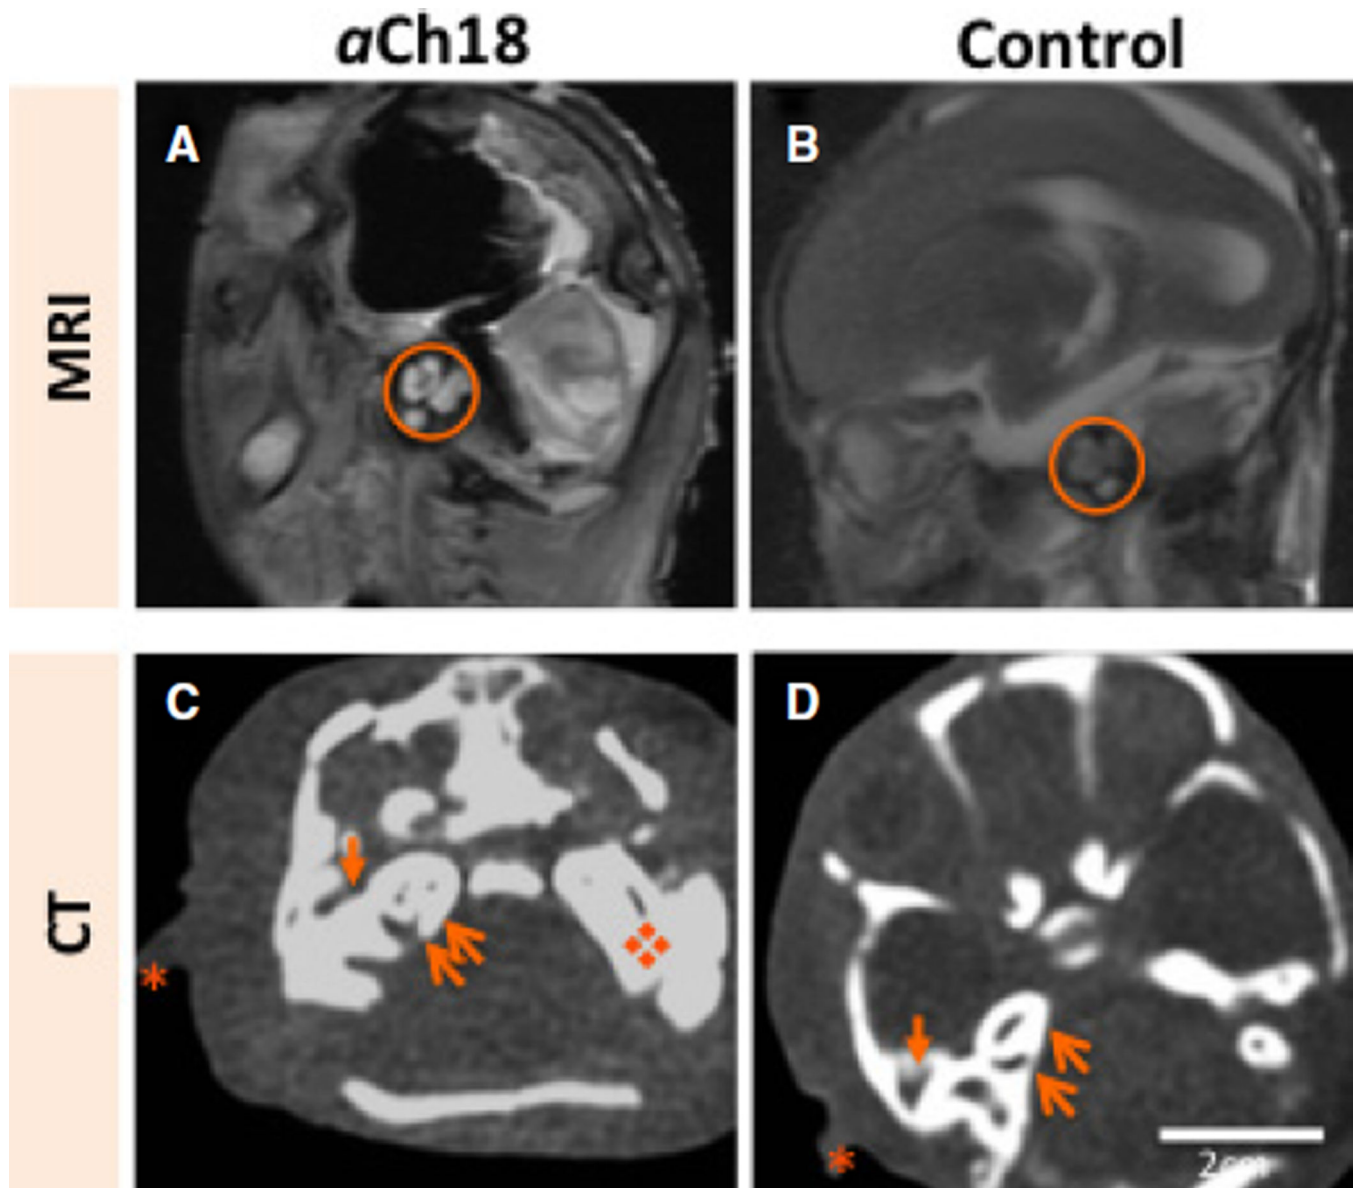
Internal, middle and external auditory structure development in HPE and cyclopia. (A) Sagittal magnetic resonance imaging (MRI) of the lateral head of an aberrant Ch18 (*aCh18*) fetus showing the middle auditory structures, mainly the ossicles (circle) appearing radiodense in *aCh18* compared with (B) the age-matched control. (C) Horizontal section of the head at the level of the inner and external ear, and the petrous temporal bone showing their presence in radiodense form compared with (D) the age-matched control. Asterisk, pinna of ear; thin arrow, cochlea; thick arrow, external ear canal; diamond, enlarged petrous temporal bone. CT, computed tomography.
